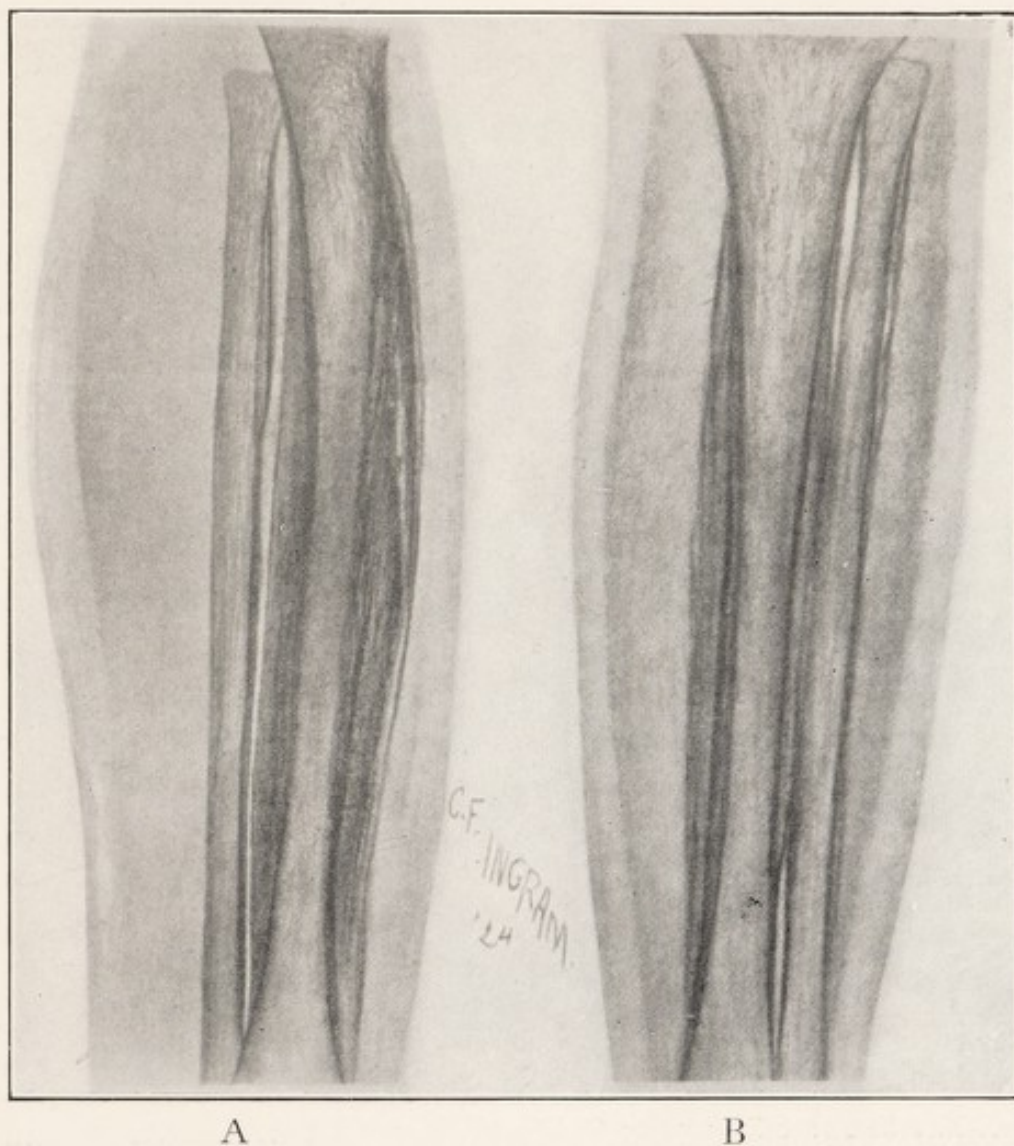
X-RAY OF SYPHILITIC PERIOSTITIS OF TIBIA, SHOWING LONGITUDINAL DEPOSITION OF NEW BONE IN LAYERS, ANTEROPOSTERIOR VIEW.
